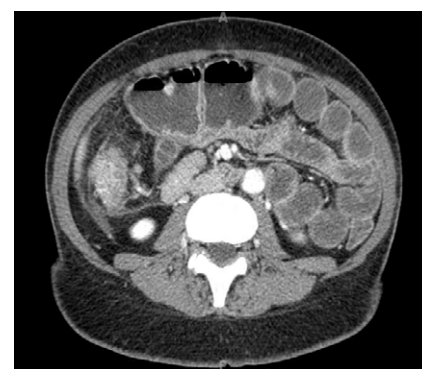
A CT scan with IV and PO contrast of the abdomen. This section of the abdomen represents the approximant level of the cecum. This particular image demonstrates a dilated segment of the small bowel that is tethered to an enteric fistula. The small bowel dilation measures approximately 5.1cm in diameter. This CT scan also demonstrates significant inflammation of the cecum that is depicted by fat stranding.
